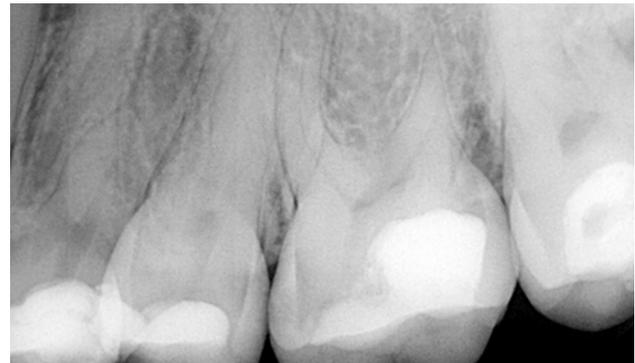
Intraoral x-ray for pre-operative assessment of crown, pulp chamber, roots and peri-radicular areas reveals apical transparency at one root of tooth #24 and several fillings in-situ
